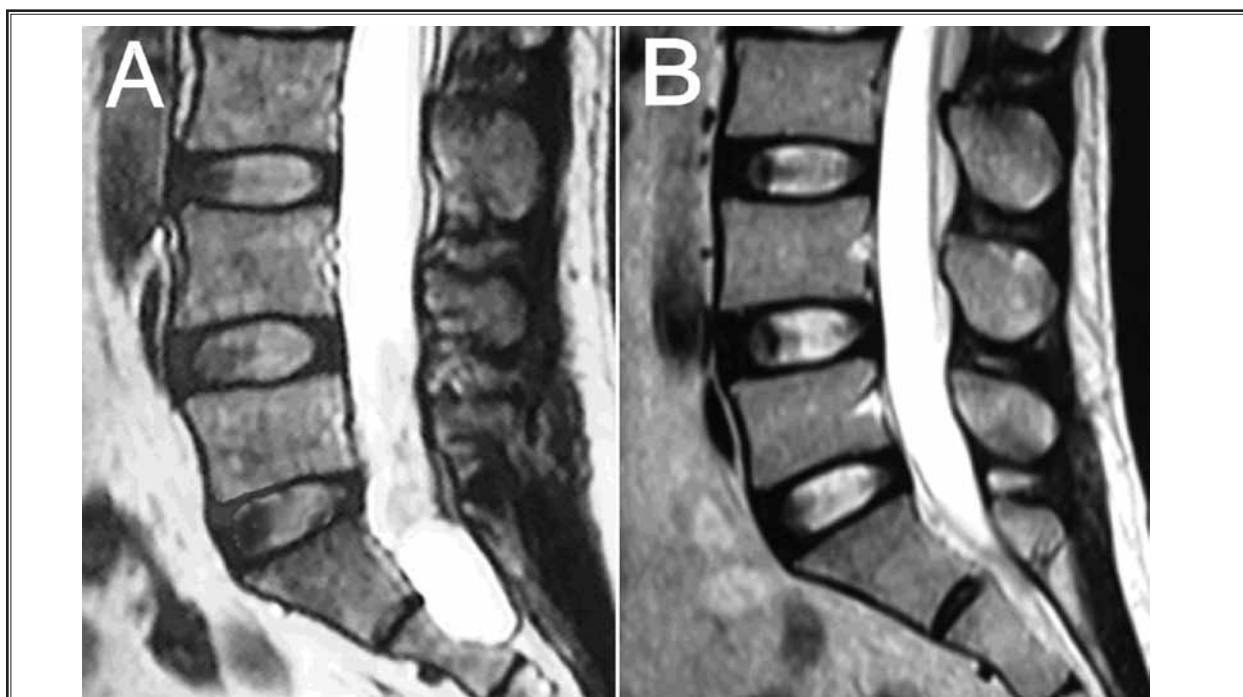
MRI study of disappearance of the cyst after C-arm fluoroscopy guided percutaneous fibrin gel injection therapy. (A) Preoperative MRI showing a 2.2 × 1.1 cm cyst in sacral spinal canal. (B) Postoperative MRI showing the cyst disappearing 5 months after the operation.
